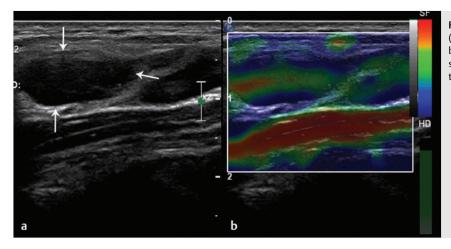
Split-screen B-mode ultrasound image (a) and corresponding strain elastogram (b) of a benign lymph node (*arrows*). The elastogram shows blue areas roughly representing <45% of the lymph node (pattern 2).
